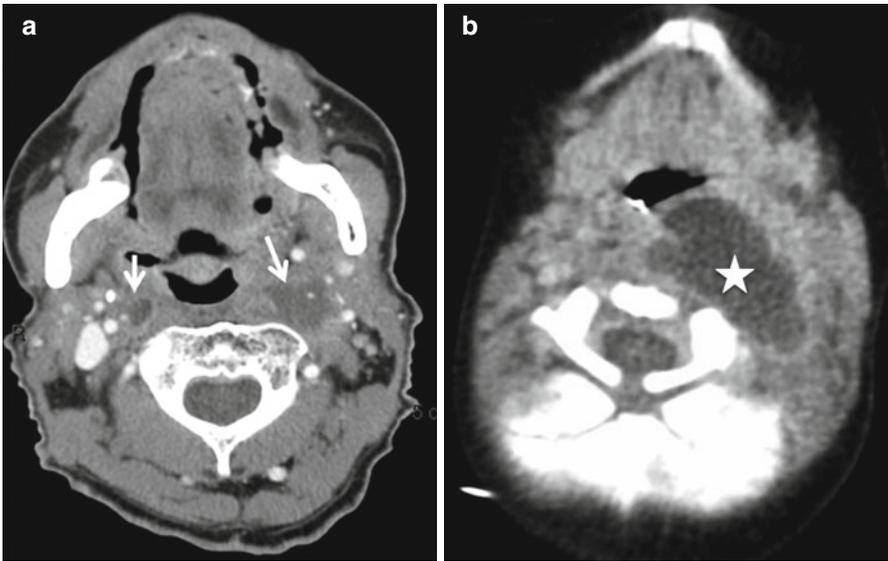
Suppurative retropharyngeal abscess. Axial contrast-enhanced CT (a) in this patient shows bilateral suppurative retropharyngeal adenopathy (*white arrow in a*). CECT in a different patient (b) with shows a large retropharyngeal abscess, presumably originating from a suppurative left retropharyngeal node. The large abscess involves the left parapharyngeal space with mass effect on the airway (*white star in b*)
